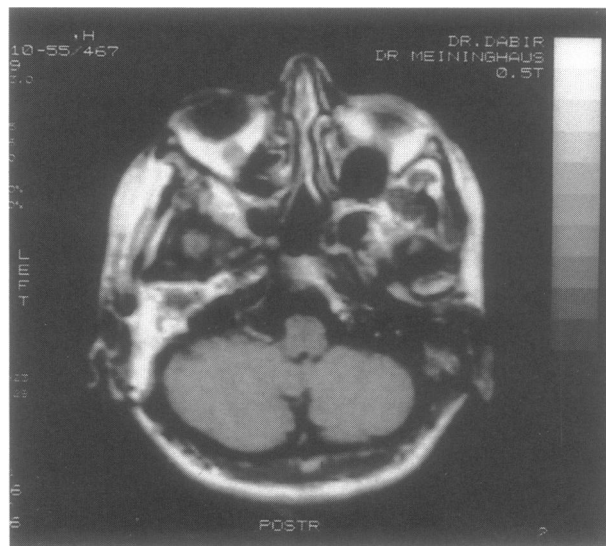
MRI of patient 1 at first presentation. A signal enhancing, soft-tissue mass occupying the left temporal bone is detected.
